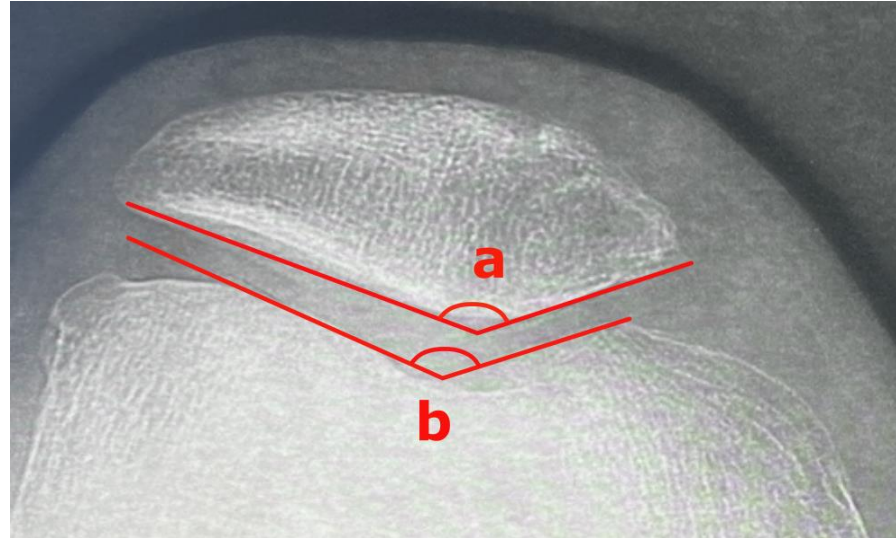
The articular surface angles are demonstrated on an axial view x-ray of a right knee. The patellar articular surface angle (PA) is based on the most posterior part of the patella and two lines along the lateral and medial facets (a). Trochlear articular surface angle (TA) is based on the deepest point of the trochlear groove and the most prominent aspects of the medial and lateral condyles (b)
